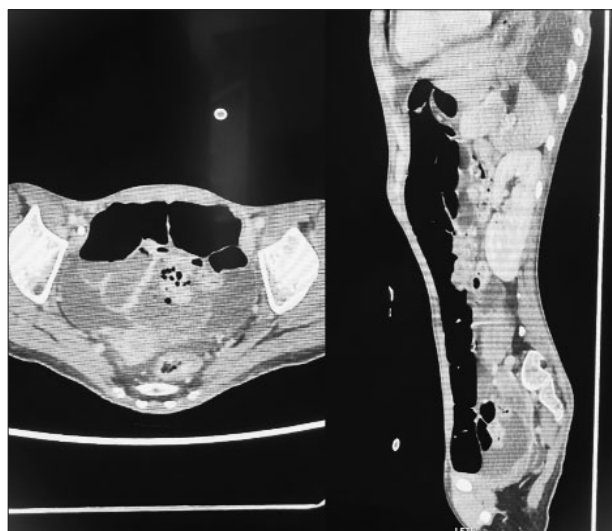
Abdominal CT scan showing typical features of sigmoid volvulus
